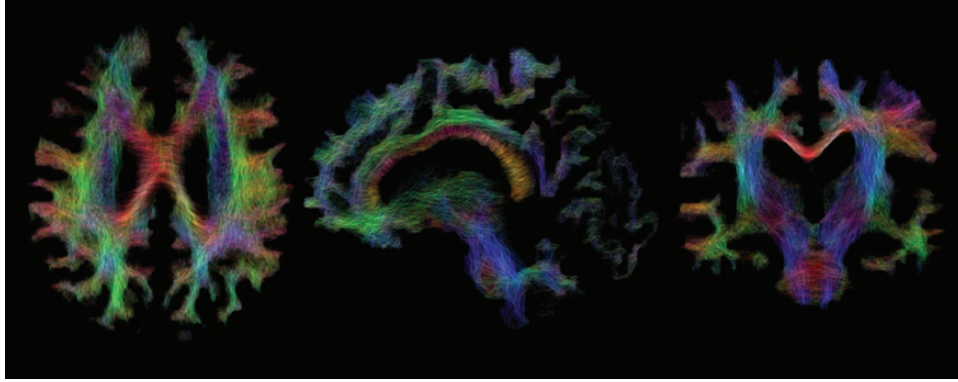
Example DWI tractogram from one SZ participant in native anatomical space (axial, sagittal, and coronal views, downsampled to 200k streamlines for display purposes). Each line represents one streamline. Line colors are assigned according to the primary directional axis of the streamline.
